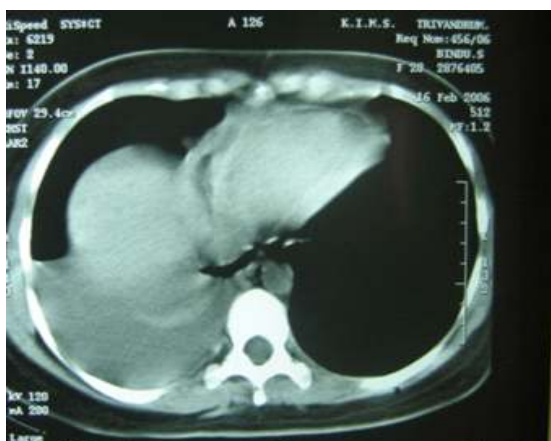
CT thorax showing hydropneumothorax
